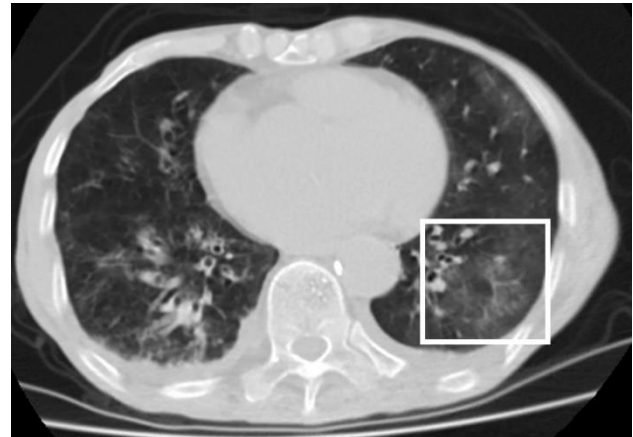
Axial non-contrast computed tomography image shows ground-glass opacity in the left lower lobe (frame).
